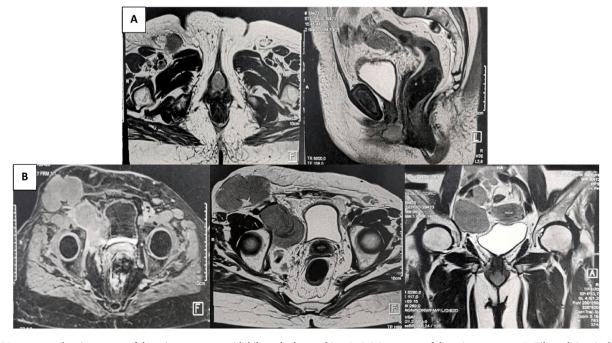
MRI sequences showing a mass of the urinary meatus, with bilateral adenopathies. A- A 2.2 cm mass of the urinary meatus. B- Bilateral, inguinal, iliac and lumboaortic adenopathies.
